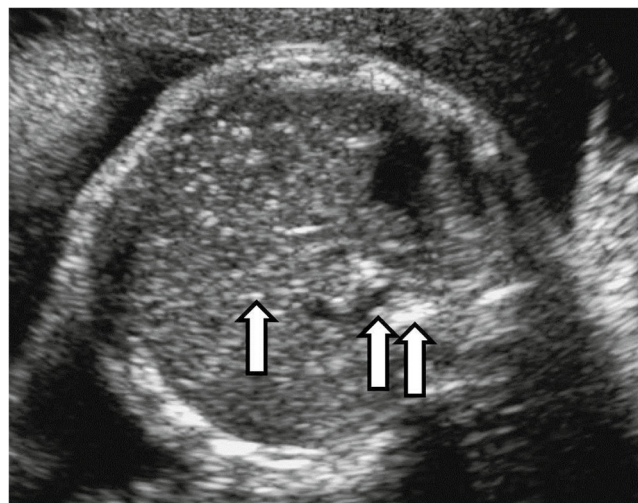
Abdomen of a fetus with congenital Rubella infection showing scattered echogenicities (arrows) within an enlarged liver From Bailao et al. *Ultrasound Quarterly*, 2005;21:4.
